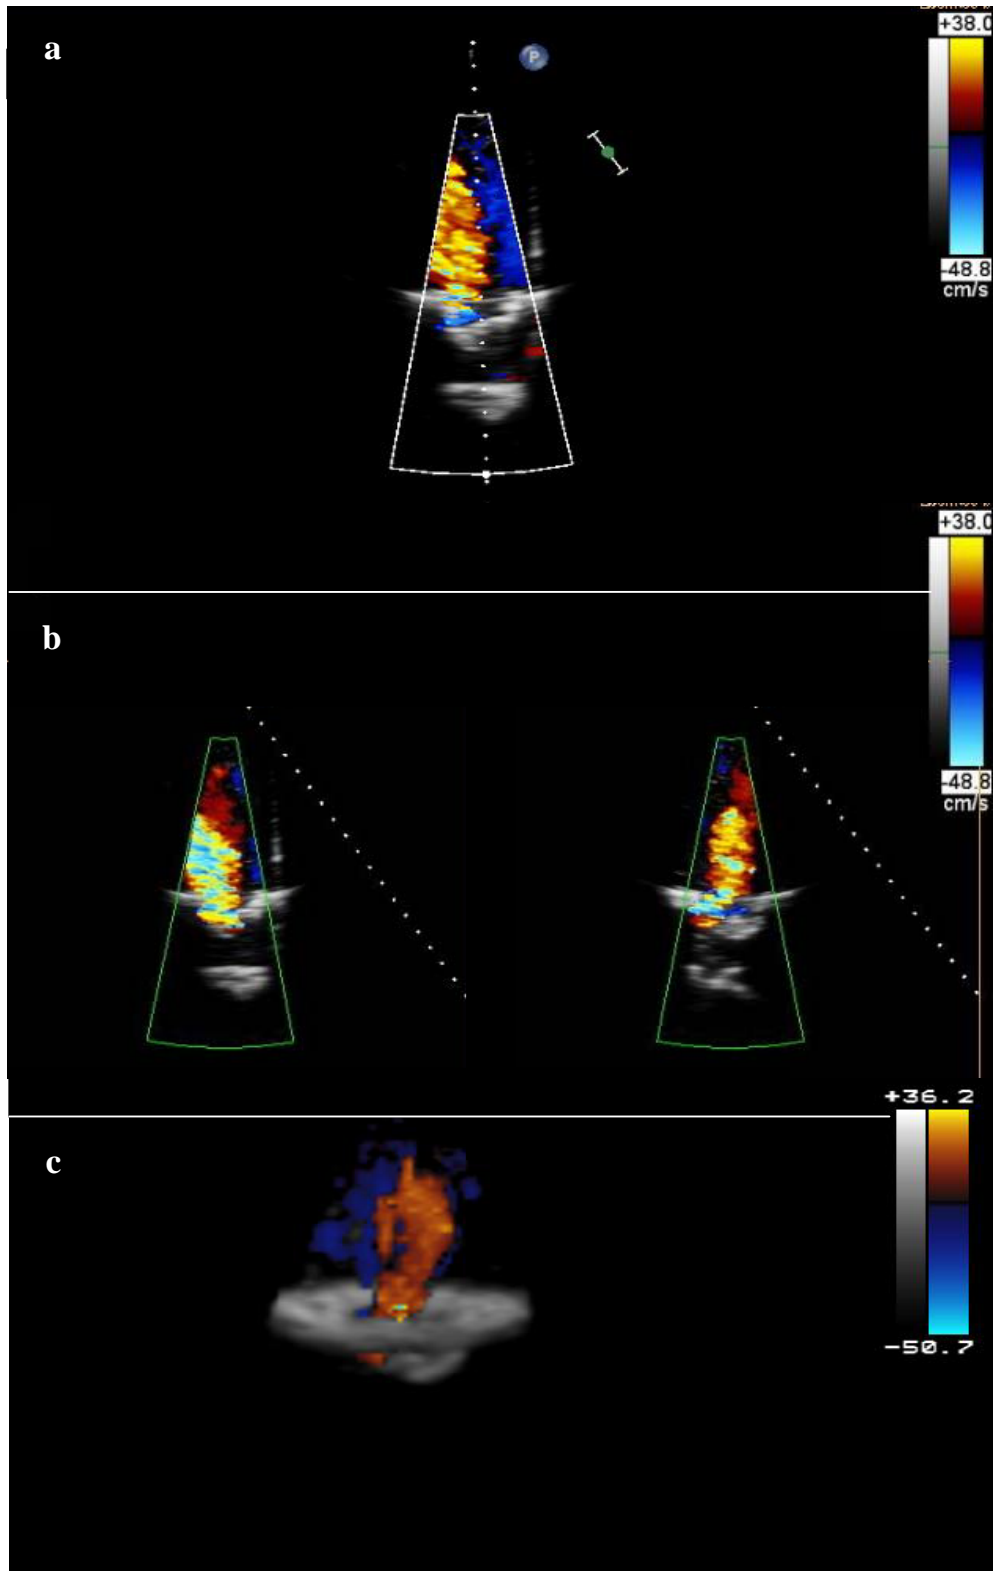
Color Doppler images of MR jets. a) shows the 2D view of the jet b) the 2D x-plane and c) a full 3D. DICOM can be found as File #51.
